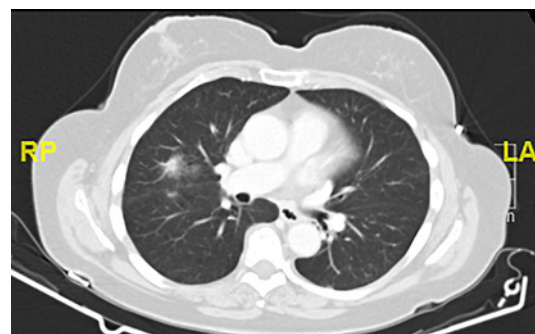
Repeat CT thorax abdomen pelvis performed on May 12, 2021. Showing the previously noted mass in the right upper lobe had reduced in size and density compared with prior studies. With the maximal axial dimension having reduced from 24 mm to 15 mm at the corresponding level.
